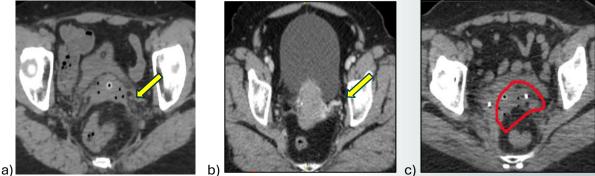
a) Uterine artery on plain CT axial image b) Uterine artery and enhancing tumor on CT axial image with IV contrast c) Using ureteric stent as markers for target extent
